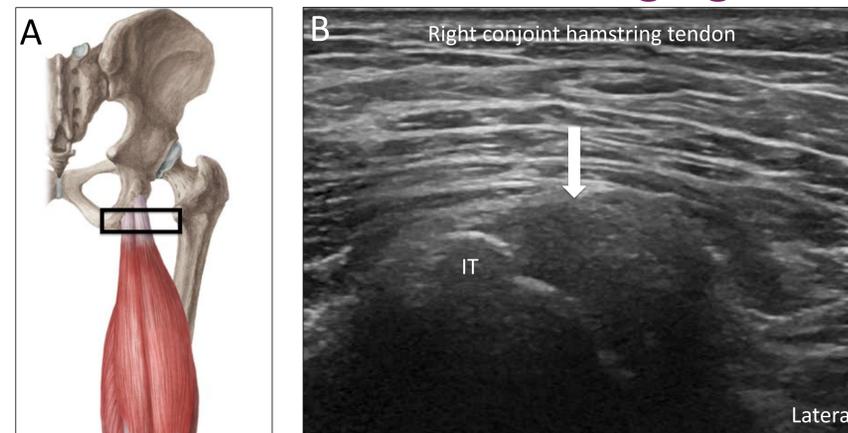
Sonographic features of acute on chronic right conjoint proximal hamstring tendinopathy. (A) Anatomy of the hamstring musculature and proximal tendon insertion. The black box indicates ultrasound probe positioning. (B) Sonographic visualization of the proximal aspect of the right conjoint hamstring tendon as it inserts on the ischial tuberosity (IT). The block arrow denotes the hypoechoic echotexture of the tendon, indicative of tendinopathy.
